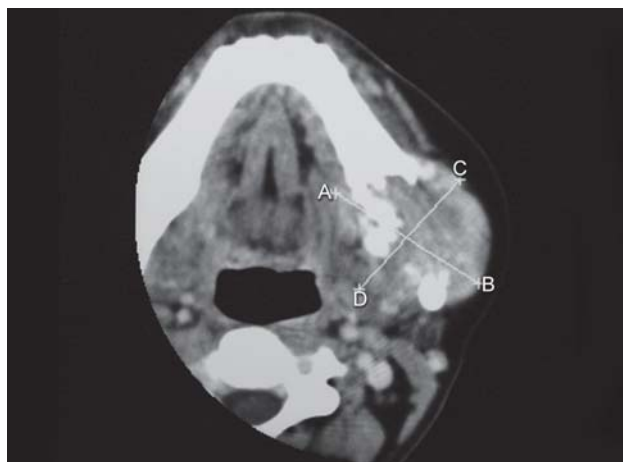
CT-transaxial sections: soft tissue density mass involving the ramus and body of the left mandible
